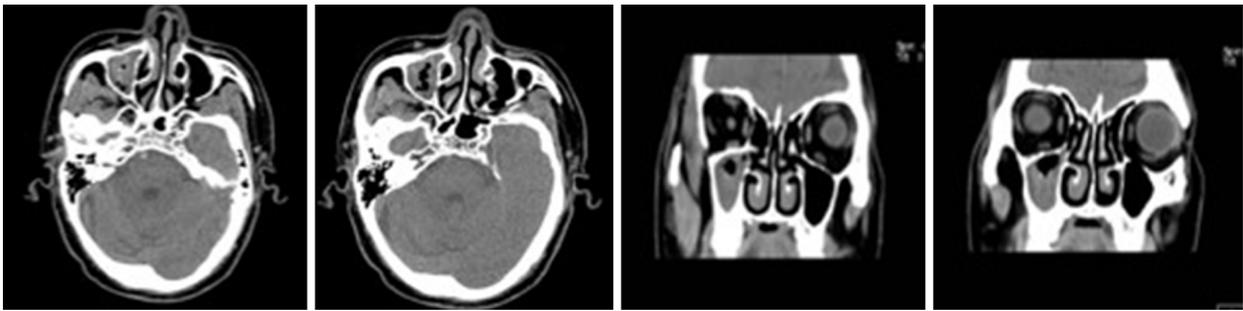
Preoperative examination (February 11, 2019). An axial and sagittal paranasal sinus computed tomography scan showed an increased patchy, dense shadow in the right maxillary sinus and sinus wall bone integrity.
